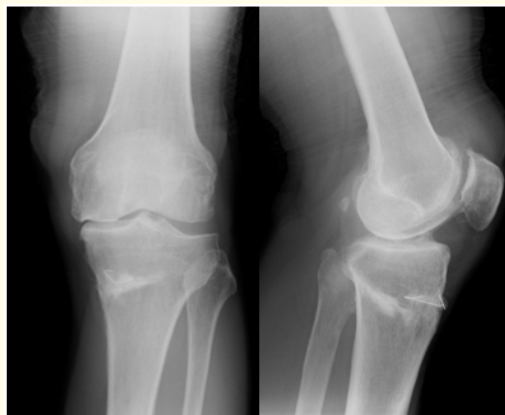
Postoperative X-ray image at 16 months after the surgery.
